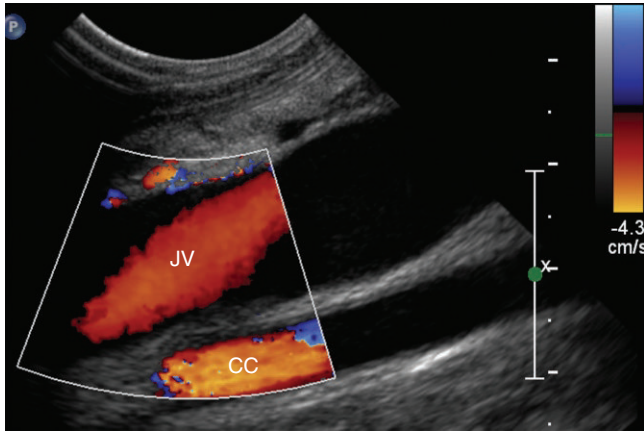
Color Doppler of the internal jugular vein (JV) and the common carotid (CC) artery demonstrates both are flowing in the same direction indicating the jugular vein is flowing in the wrong direction. Reversed flow is possible in upper extremity veins in the neck and thorax because collaterals can cross the neck or mediastinal to return flow to the heart.
